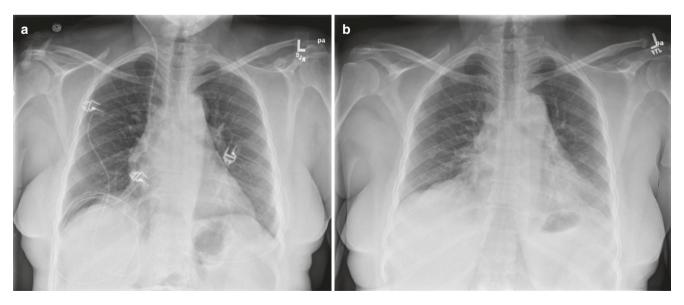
Shrinking lung in a patient with SLE due to diaphragmatic myopathy. (a, b) Serial radiographs 6 months apart with worsening symptoms showing poorer diaphragmatic excursion
